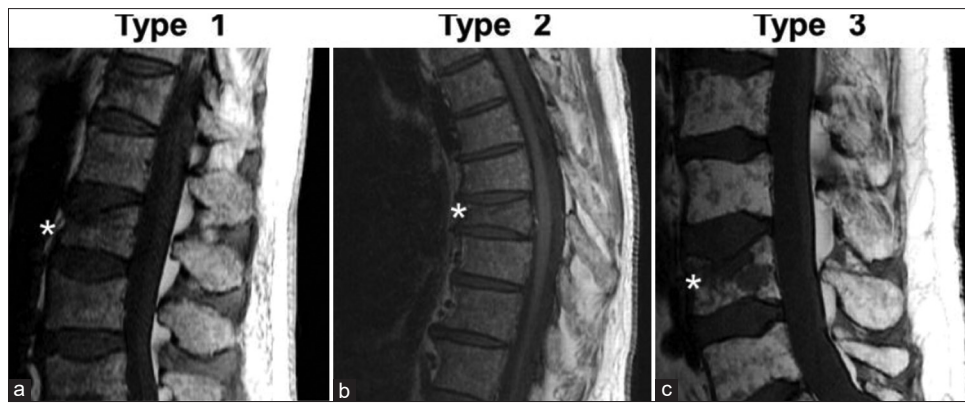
Sagittal magnetic resonance imaging T1 according to the types of fractures. The stars show the postoperative fractures. (a) Osteoporotic fracture Type 1 fracture, osteoporotic type. Note the high intensity of the T1 signal, preserved according to the fractured vertebral body. There is no focal intervertebral lesion and there is no evidence at the pedicle level of epidural or paraspinal involvement. (b) Traumatic fracture Type 2 fracture, uncertain of underlying injuries. There was no focal, epidural, or paraspinal lesion in the treated vertebral body. (c) Myelomatous fracture Type 3 fracture, clear evidence of a myelomatous lesion within the vertebral body
